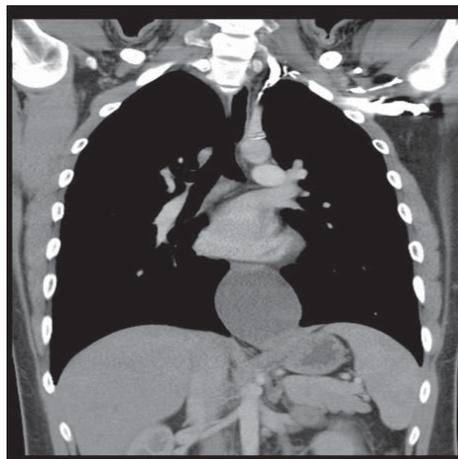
CT scan of the oesophageal duplication cyst (coronal view).
